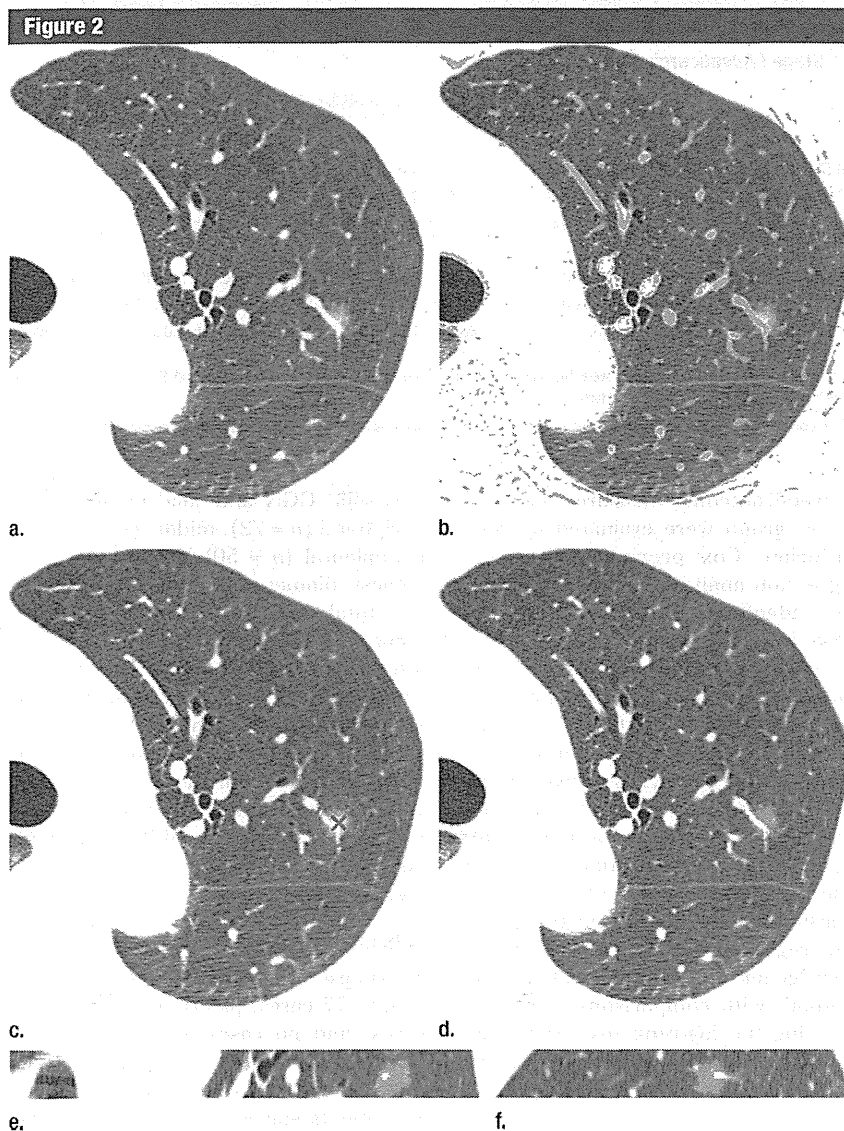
Images show sequential steps in volumetric analysis of a pure GGN in a 57-year-old woman. (a) Thin-section CT image shows a pulmonary vein traversing an 8.1-mm GGN in the left upper lobe. (b) Three-dimensional line filter identifies and extracts vessels (green areas). (c) An over-inclusive region of interest is drawn manually around the nodule in red. (d) Axial image, (e) coronal image, and (f) sagittal image of GGN. Nodule is automatically segmented (shown as highlighted green area) with calculation of GGN and solid components. Total volume, solid volume, and percentage of solid volume for this nodule are 0.14 cm³, 0.00 cm³, and 0.00%, respectively.
